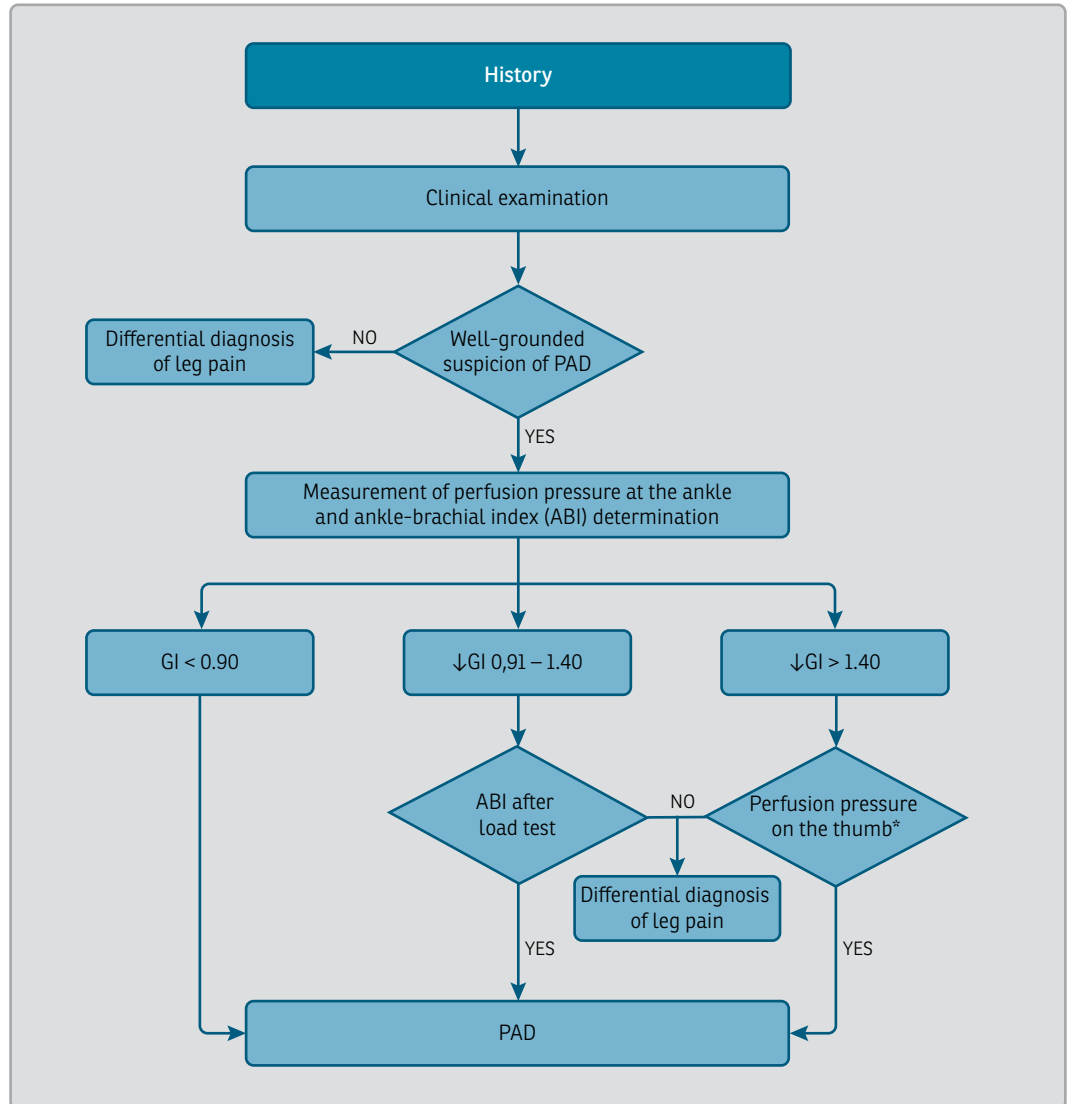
Diagnostic algorithm for suspected peripheral arterial disease (PAD). Adapted from 1 and 2. d.d. – differential diagnosis, obremen. – load test, perfuz. – perfusion. *In incompressible shin arteries, PAD can be also proven by ultrasonography of the arteries or by another imaging method.
